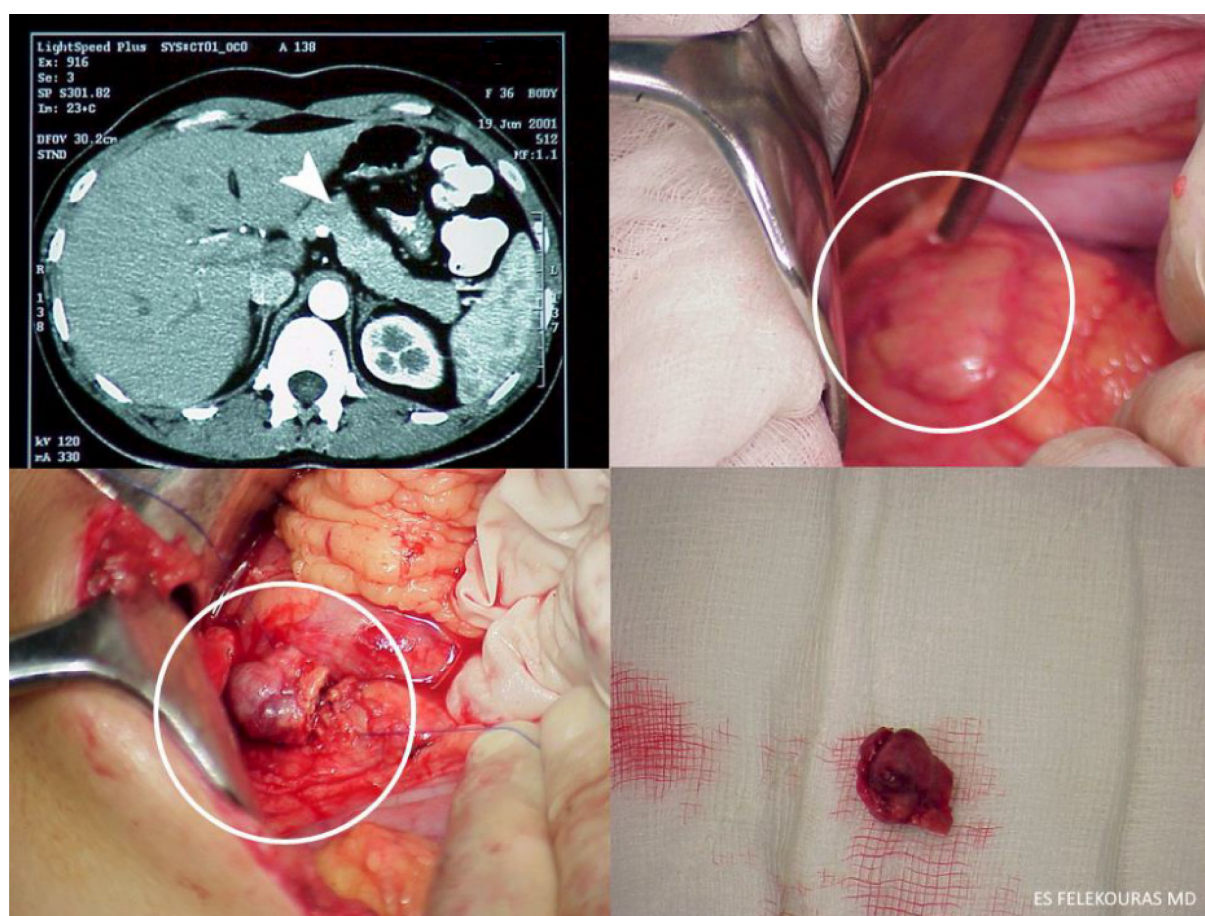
Open enucleation of insulinoma located in the body of pancreas that was preoperatively detected in CT. A small gray-red tumor was identified after resection and incision.
